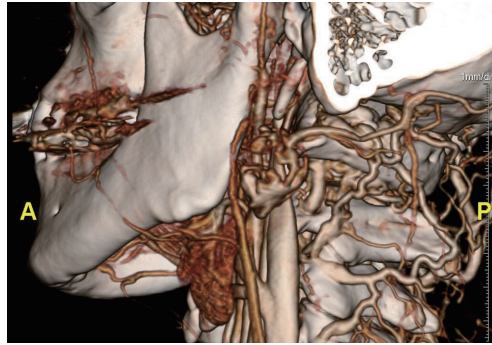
Computed tomographic angiogram showing the pseudoaneurysm along the course of the proximal occipital artery. A, anterior; P, posterior.
